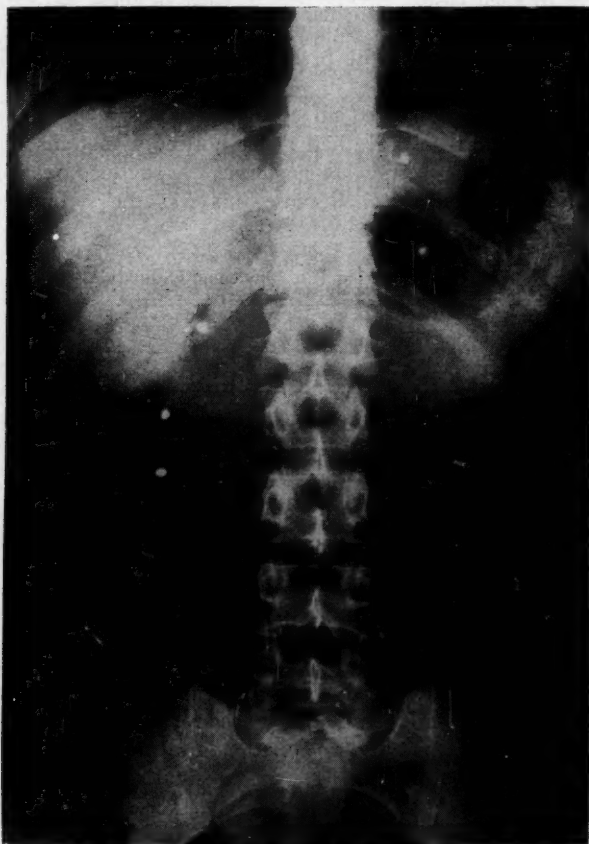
Abdominal scout roentgenogram, showing opacities of multiple weights attached at intervals along the string. The duodenal loop is readily identified. The extra weights traumatized the mucosa, and this technic was discontinued.
